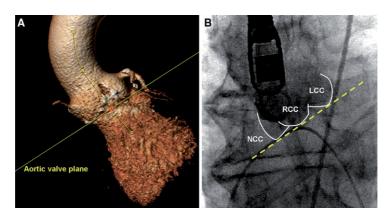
Planning of angiographic planes. Using reformation reconstruction of multidetector row computed tomography (MDCT), the appropriate aortic valve plane for transcatheter aortic valve implantation can be anticipated (a). The ideal
